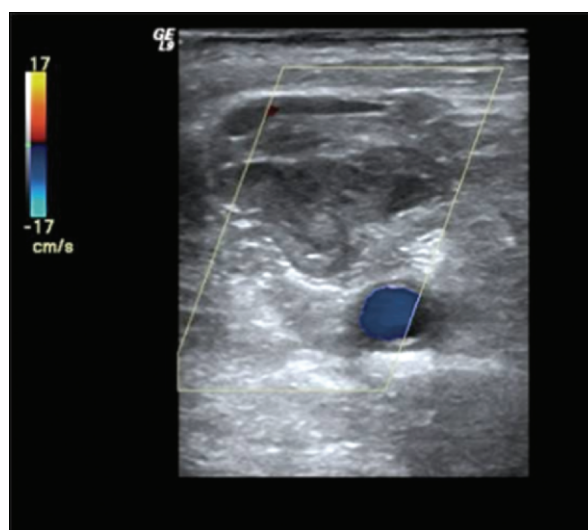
Axial color-flow Doppler ultrasonographic image in an orientation similar to that seen in Figure 2, after the injection of thrombin, shows thrombosis of the pseudoaneurysm with maintained flow in the common carotid artery.
